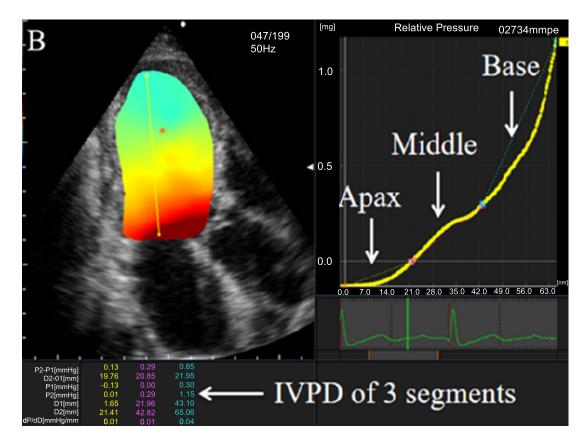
The ultrasound measurements of EL (A) and IVPD (B) using VFM. (A) The LV was divided into three segments. EL\_AVE is the averaged EL. (B) P2-P1 is the IVPD.
